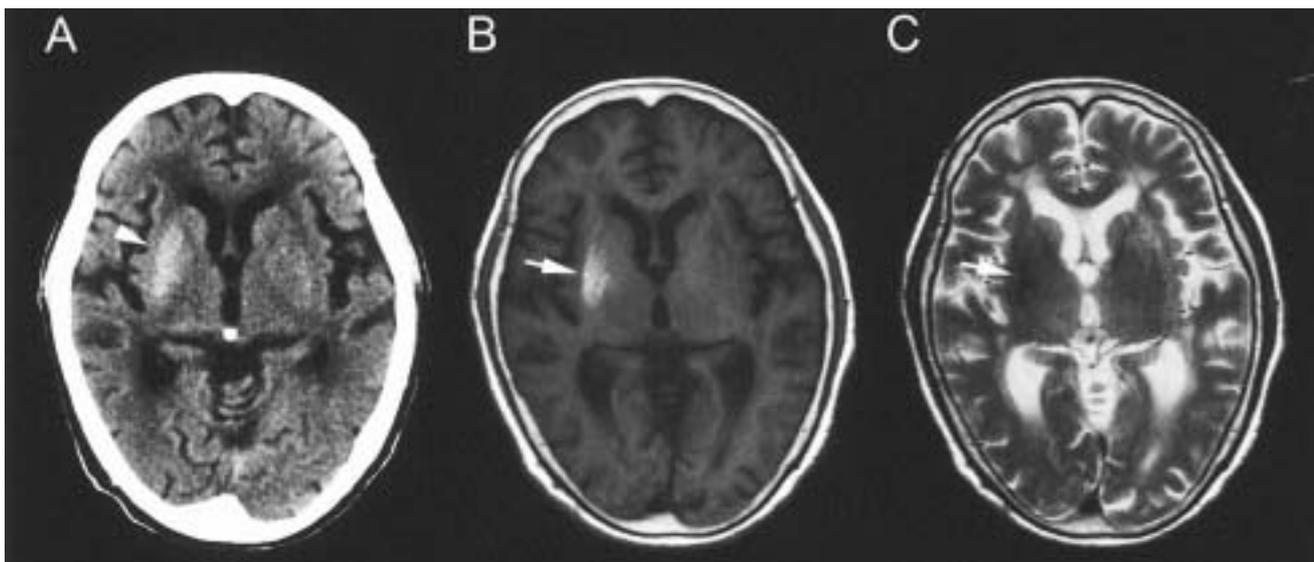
Neuroimaging studies of patient 1. The right putamen (arrowhead) was hyperdense on noncontrast CT (A). Transaxial T1-weighted MRI (B) demonstrated increased signal intensity in the right putamen (arrows), which was hypointense on T2-weighted images (C).
